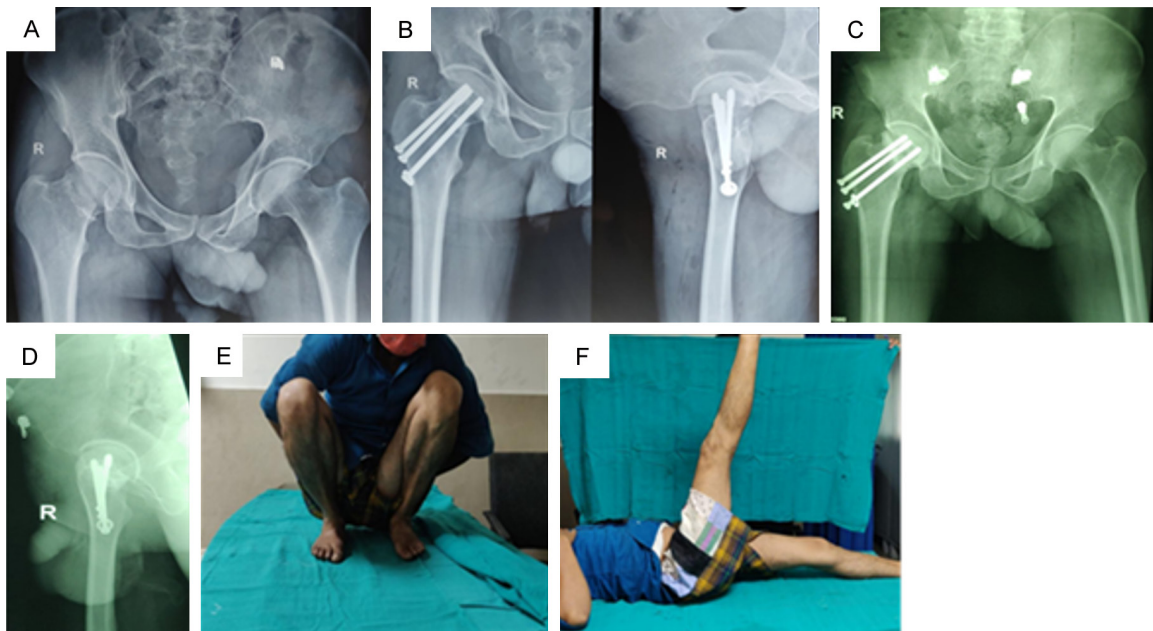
35 year/male patient presented with injury to right hip. X-ray showed fracture neck of left femur (A), CRIF with three CCS was done. Immediate postoperative x ray showed screws in inverted triangular configuration (B), X-ray at 1 year follow-up showed union with some neck shortening (C, D), Functional outcome at 1 year (E, F).
